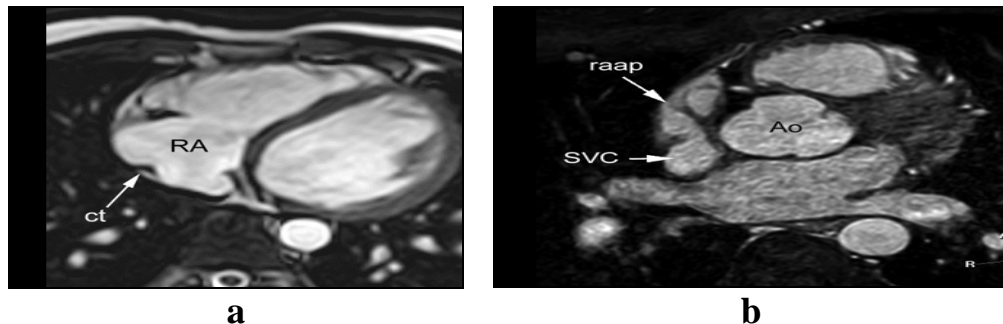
Right atrium, the crista terminalis (CT) divides the venous component (posteromedially) from the vestibule. Right atrial appendage (raap) is located ventrally to the superior vena cava (SVC) and laterally to the ascending aorta (Ao) (*Broderick et al., 2005*).
